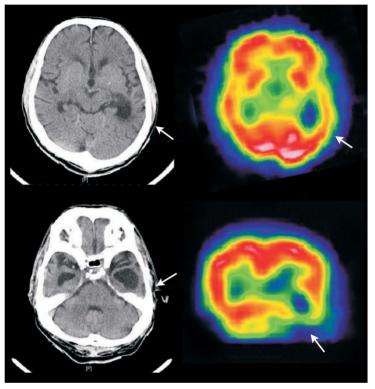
Axial CT images show relatively intact left anterior temporal lobe and significant atrophy of the left posterior temporal lobe (the arrows). [Tc99m] ECD (ethylene cysteinate dimer) cerebral perfusion scan also reveal decreased perfusion of the left posterior temporal lobe (the arrows).
